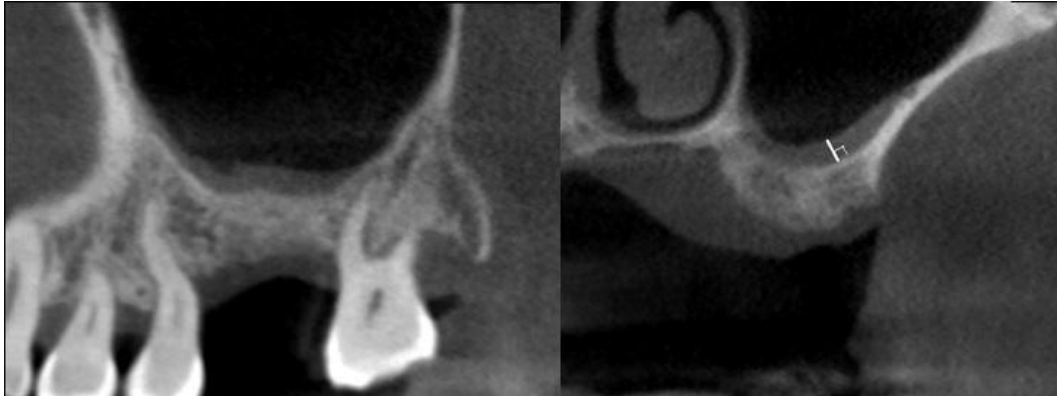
a) The cone beam computed tomography image of a maxillary sinus with a thick membrane (sagittal slice). b) The thickness of the sinus membrane was evaluated in cross sectional view.
